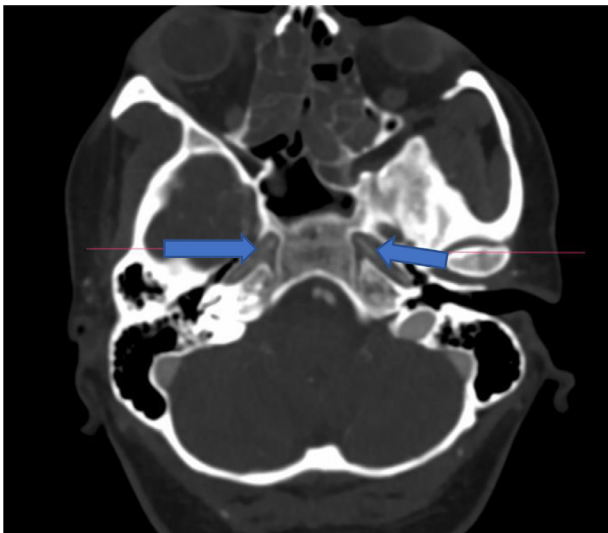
CT angiography: axial image showing reduced calibre of bilateral ICA.
